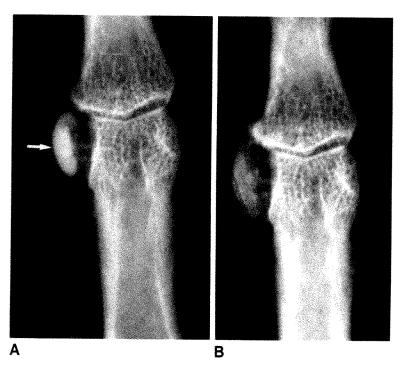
A, Radiograph shows dense calcification along radial aspect of proximal interphalangeal joint (*arrow*) in patient with calcific periarthritis who had acute pain, swelling, and erythema locally.
